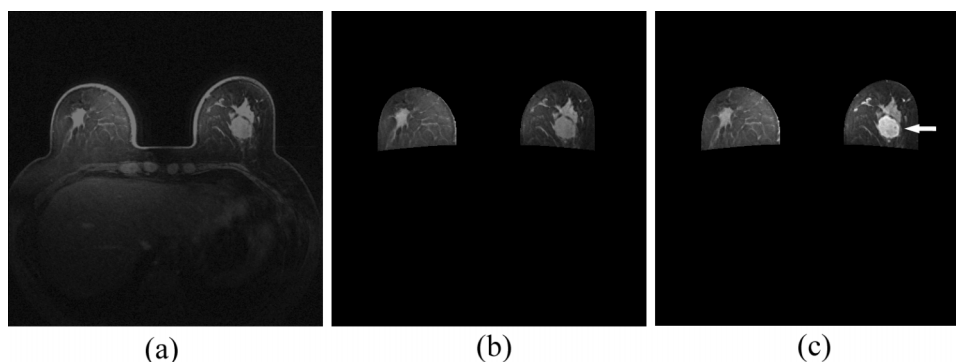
An example of a breast DCE-MRI slice (a) and its CAD-segmented breast regions depicted on the image slice before (*S*-0) and after (*S*-1) contrast agent injection [(b) and (c)] in which the nonbreast regions behind the chest wall are removed and a tumor is pointed by a white arrow on the *S*-1 image slice.
